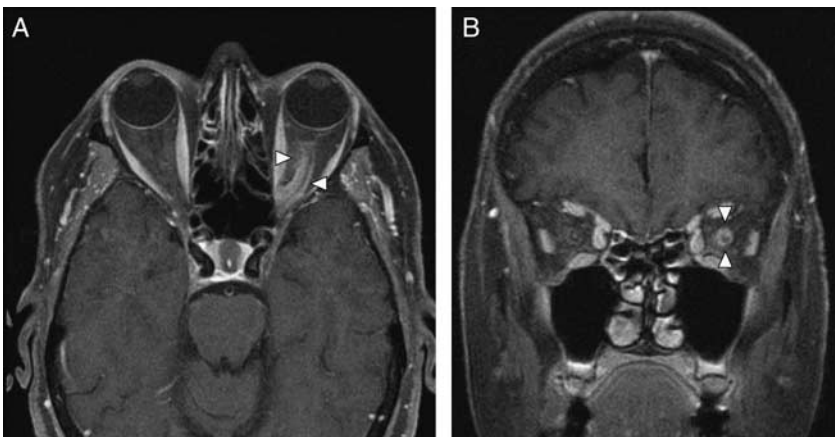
75-year-old woman presented to her ophthalmologist with a left visual field cut and was found to have an optic nerve sheath meningioma. Axial (A) and coronal (B) T1-weighted postcontrast fat-saturated magnetic resonance imaging demonstrates diffuse thickening and enhancement of the left optic nerve sheath with relative sparing of the optic nerve (white arrow heads).
